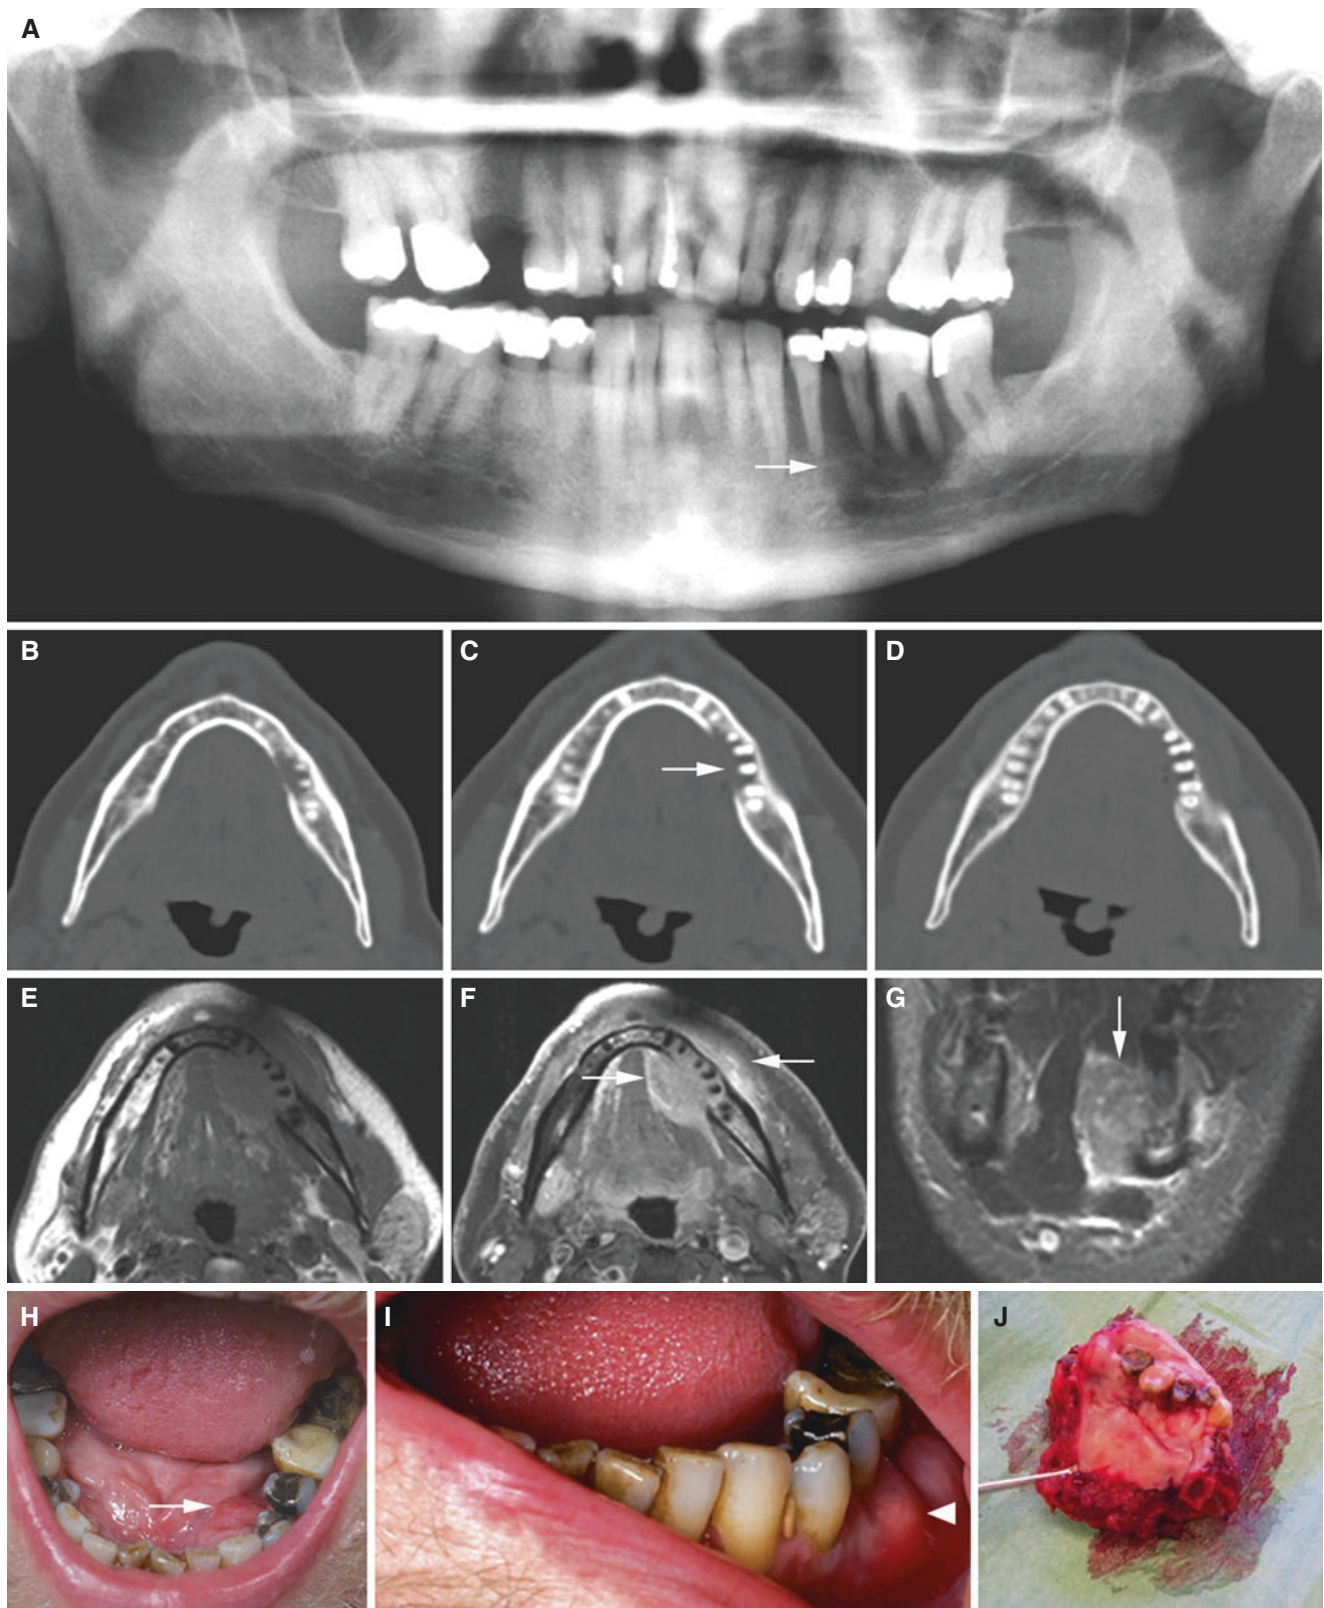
Squamous cell carcinoma, mandible; 60-year-old male with pain-free mass and two loose teeth in left mandible. (A) Panoramic view shows destruction in alveolar ridge in left mandible (arrow). There is normal periodontal bone level in other parts of dentition. (B, C, D) Axial CT images show destruction of lingual cortical bone (arrow). (E) Axial T1-weighted pre-Gd and (F) axial T1-weighted fat sat post-Gd MRI
